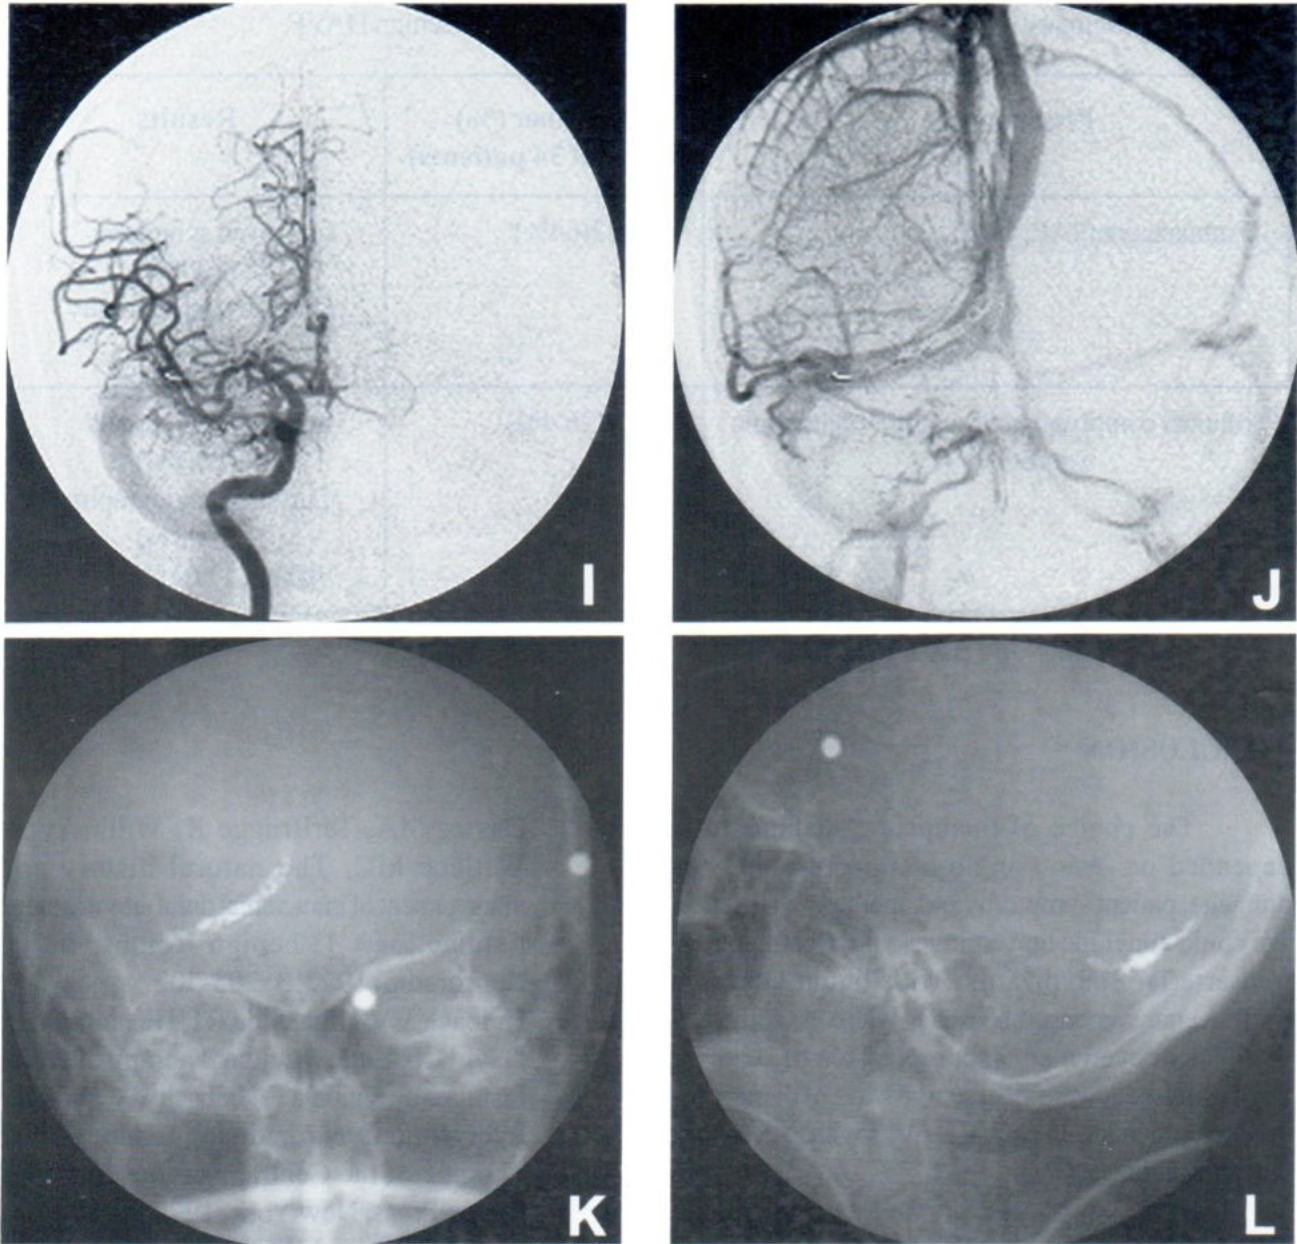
Successful transvenous coil embolization into septated portion of Rt.transverse sinus. A 49-year-old man with history of Rt.hemiplegia and cognitive impairment and blurred vision. Prior MRI& MRA (A-D) is suspicious of vascular shunts at Rt.transverse sinus with Lt. transverse sinus thrombosis and diffuse cortical venous reflux, Dural AV fistula is likely, with white matter infarction at left periventricular white matter and centrum semiovale(not shown). Pretreatment Cerebral angiography(E-H) shows Dural AVF at Rt. transverse-sigmoid sinus, at septated portion(arrow), supplied from dural branches of Rt.ECA, Lt.ECA and Rt.ICA and thrombosis of Lt. transverse sinus. Control cerebral angiography of Rt.ICA after coil embolization(I,J) and Skull radiograph(K,L) showed position of coils placed only in pathologic septated sinus. Immediate decreased cortical reflux in both supra- and infratentorial systems are apparent. However, complete closure of other shunts at this transverse-sigmoid sinus of this patient is obtained after combined glue(NBCA) embolization into few branches of Rt.ECA afterward.
